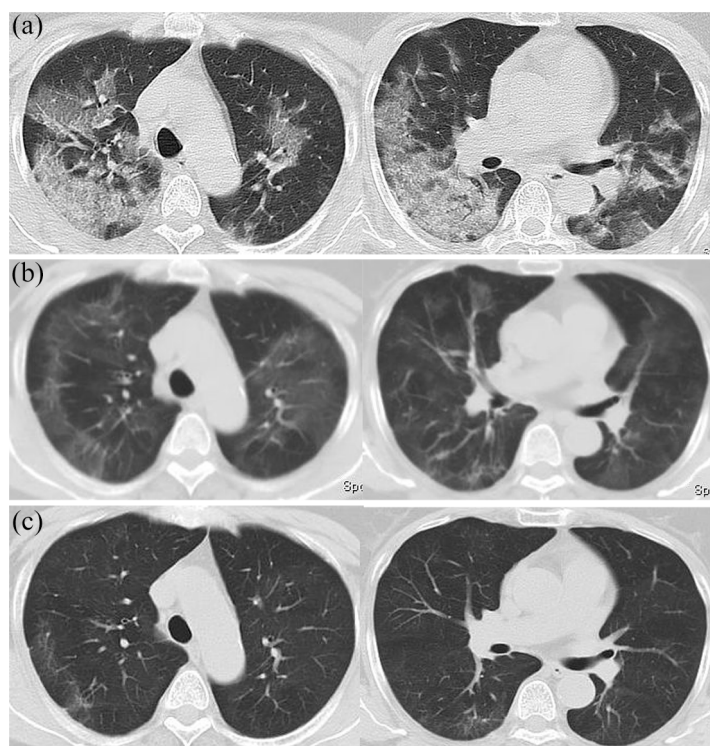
Chest CT images of patient with COVID-19 in hospital and 1 and 3 months after discharge. (a) CT image on day 6 after symptom onset showing worsening of bilateral GGOs with mixed linear opacities. (b) CT images showing improvement in bilateral GGOs at 4 weeks follow up. (c) CT images showing the near-complete resolution of bilateral GGOs at 3-month follow up after discharge.
